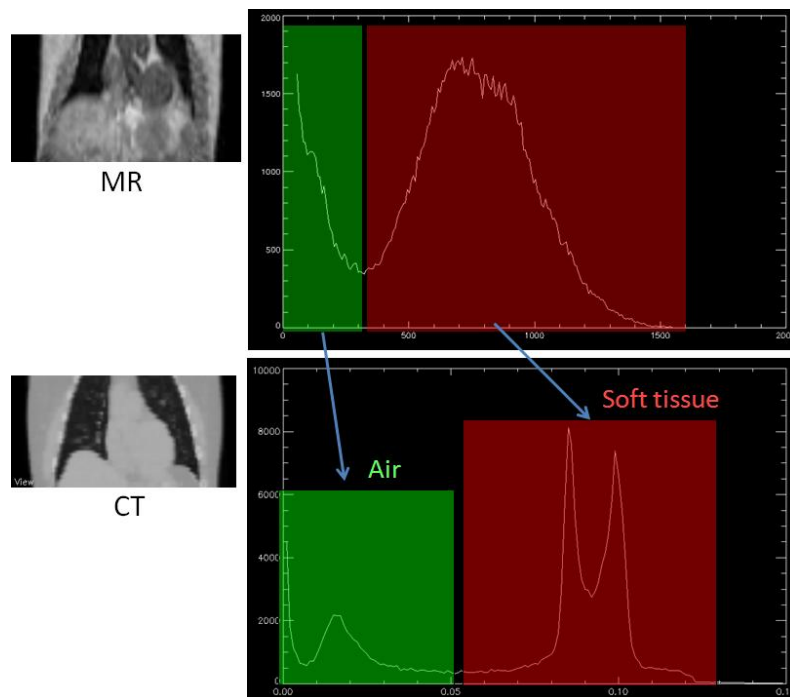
In the first proton-weighted acquisitions, the MRI histogram showed two different peaks for air (including the lungs) and soft tissue.
